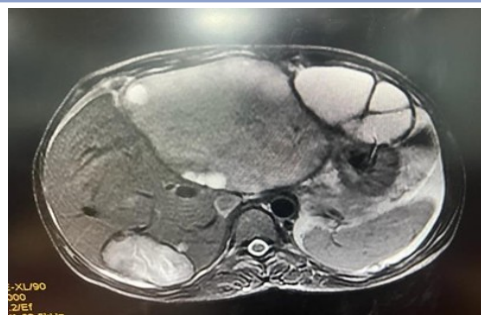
Showing MRI T2 axial view with multiple hyperintense cystic lesions with variable sizes showing few thin septae within
